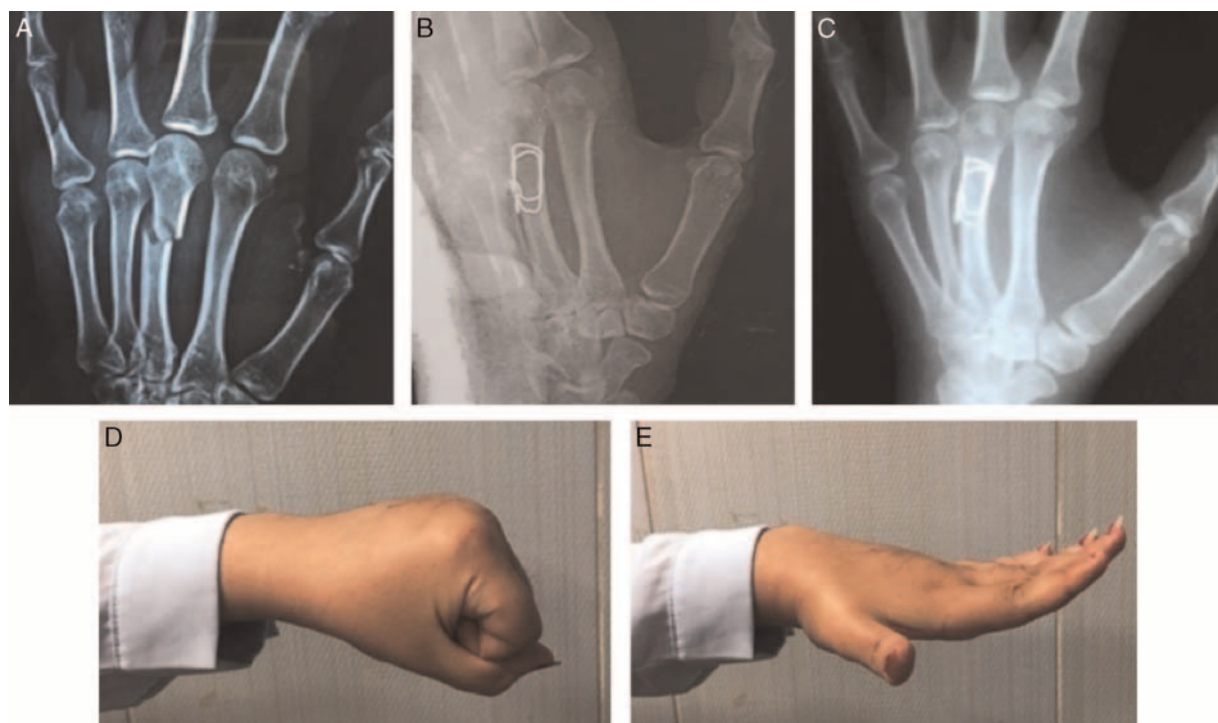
(A) A 24-year-old male patient with short oblique fracture of the second metacarpal of the left hand. (B) Immediate postoperative radiograph. (C) Complete union with mild varus.
